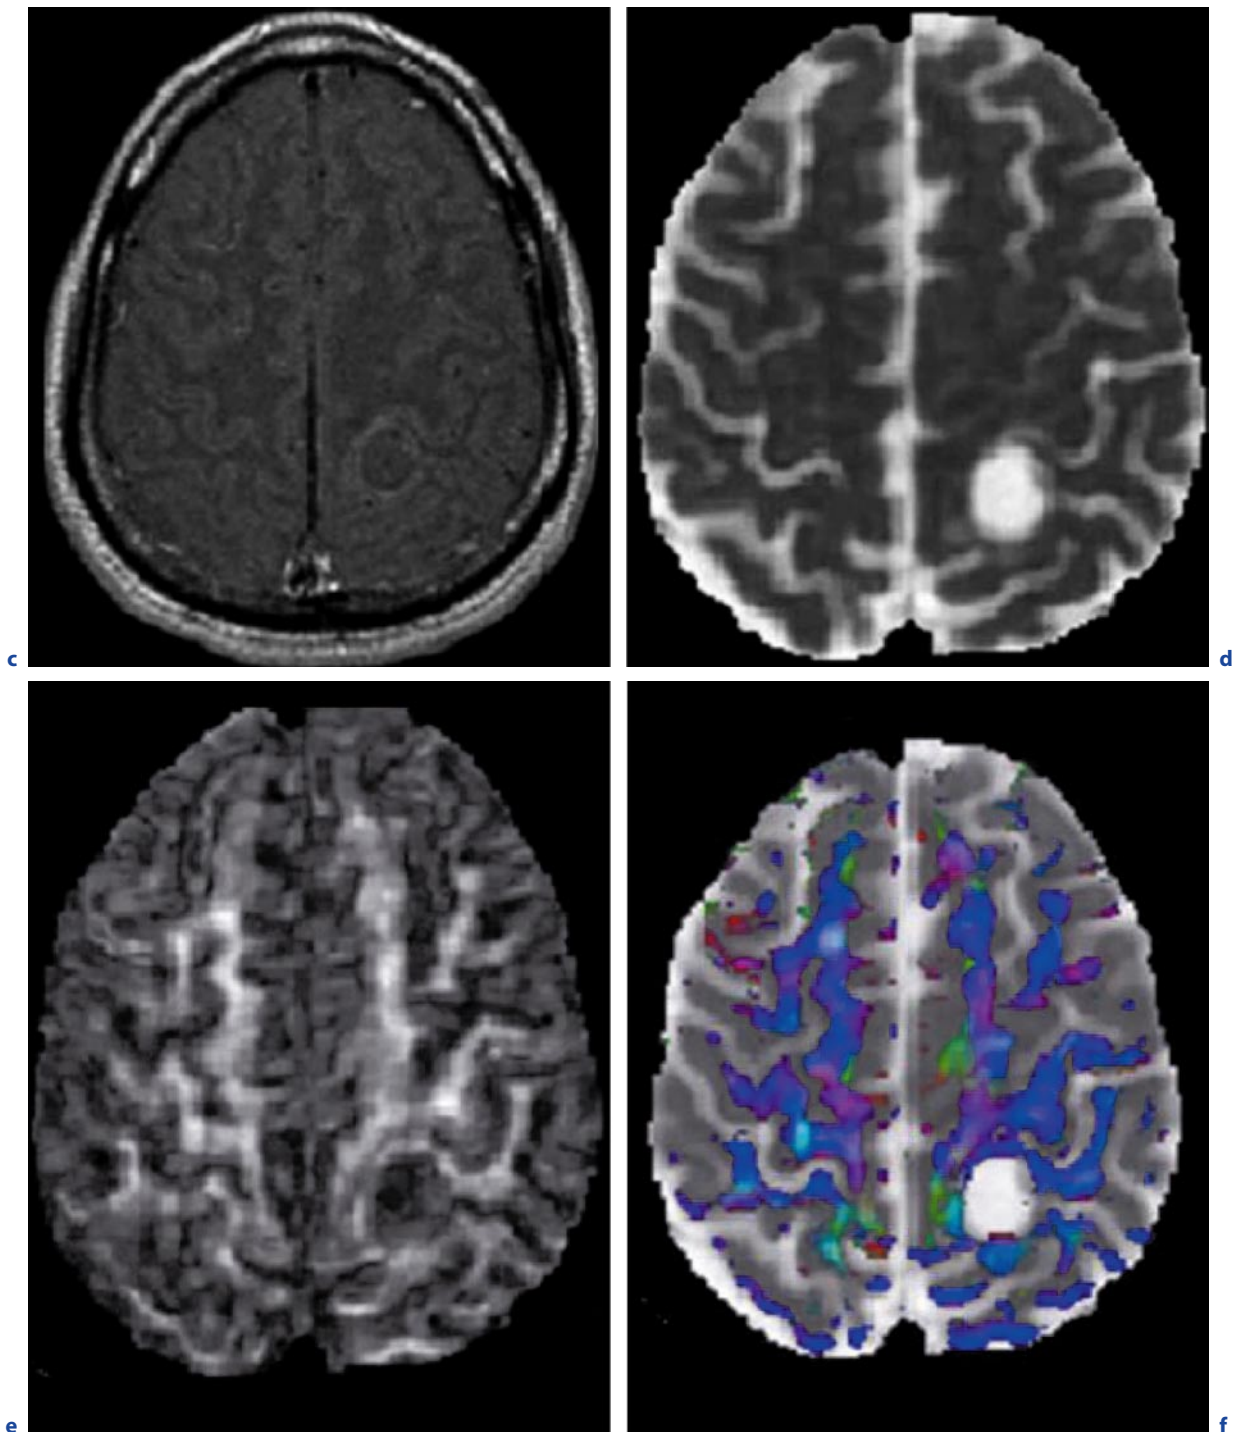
(continued) Neurocysticercosis in a 40-year-old man who presented with headache. c Axial T1-weighted image after contrast administration with MT contrast. d Axial ADC map. e FA map. f Color-modulated FA map. g Proton MRS. Hyperintense cyst on the left side with eccentrically placed hypointense scolex on T2-weighted image. The lesion appears
